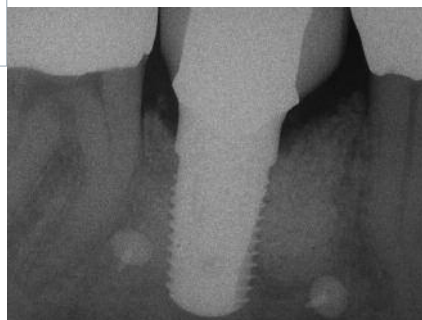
Radiographic follow-up four years after insertion shows the apparent stability of the periimplant tissue (see Fig. 26)
